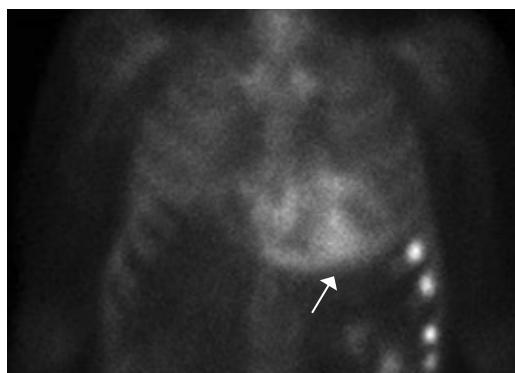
99mTc-DPD scintigraphy: intense cardiac uptake (arrow) of the radiotracer is observed in both ventricles (Perugini score 3), with mild diffuse bone uptake that is higher in the broken left ribs.
